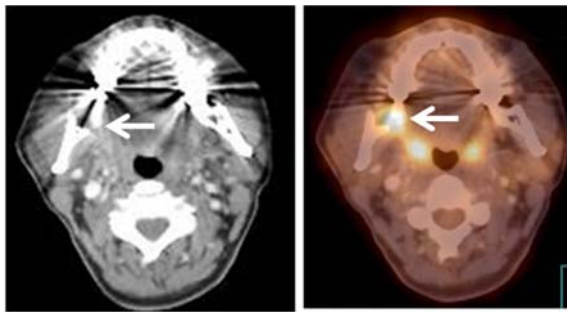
A 55-year-old female with a history of gum cancer underwent wide excision and marginal mandibulectomy for 2 weeks. CT scan and fused PET/CT scans show increased FDG uptake (arrow) at right lower gum with SUV_{max} of 3.7. No soft tissue or bone mass is demonstrated on accompanying slices CT scan
